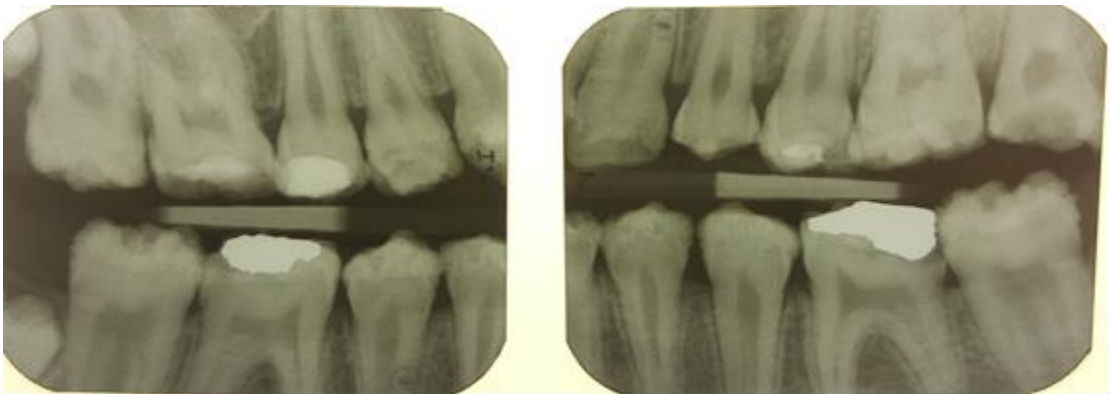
Horizontal Bitewing Radiographs 18-6-2015
